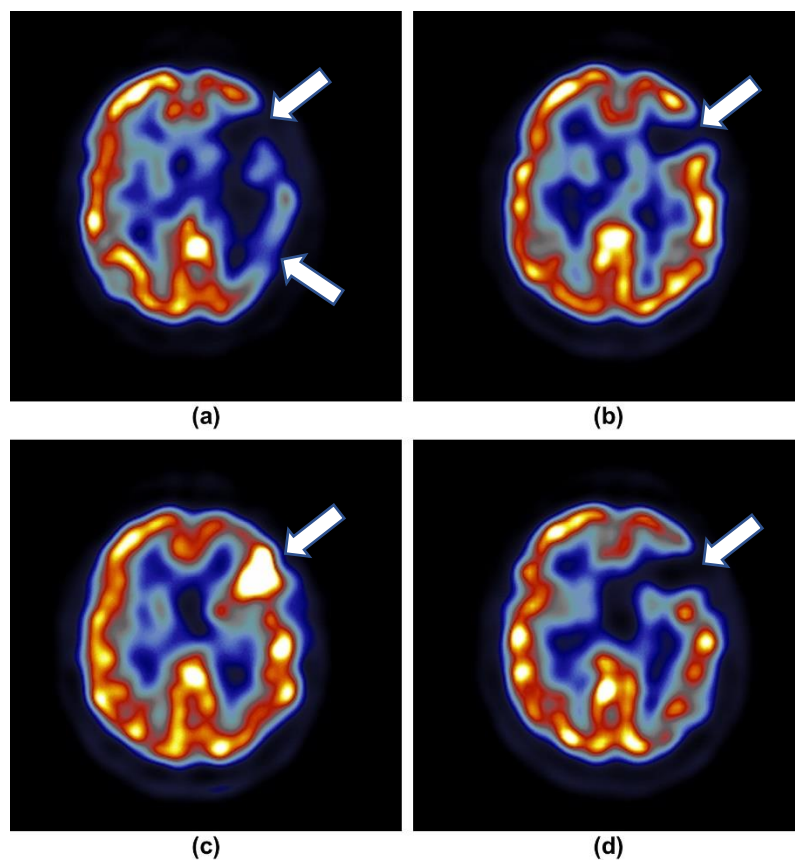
SPECT scan acute and subacute images post-stroke. (a) acute infarct core and hypoperfusion (b) likely infarct core (c) luxury perfusion two weeks post stroke (d) final infarct volume four months post-stroke. Reprinted with modification from *Clinical Radiology*, Volume 66, McArthur, C., Jampana, R., Patterson, J., & Hadley, D. Applications of cerebral SPECT, pages 651-661, Copyright (2011) with permission from Elsevier
